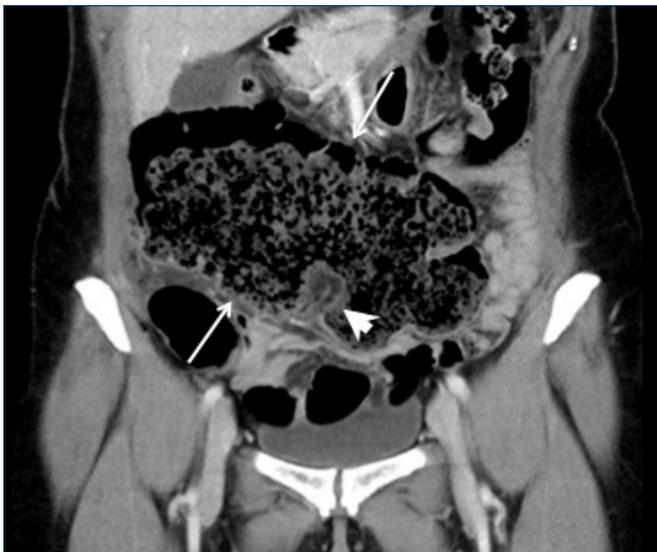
Coronal CT image at the level of the ileocecal valve (arrowhead) confirms a dilated, stool filled cecum (arrows).
